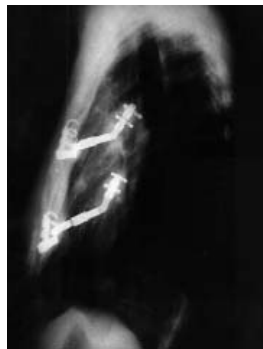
Left profile post-operative X-ray
